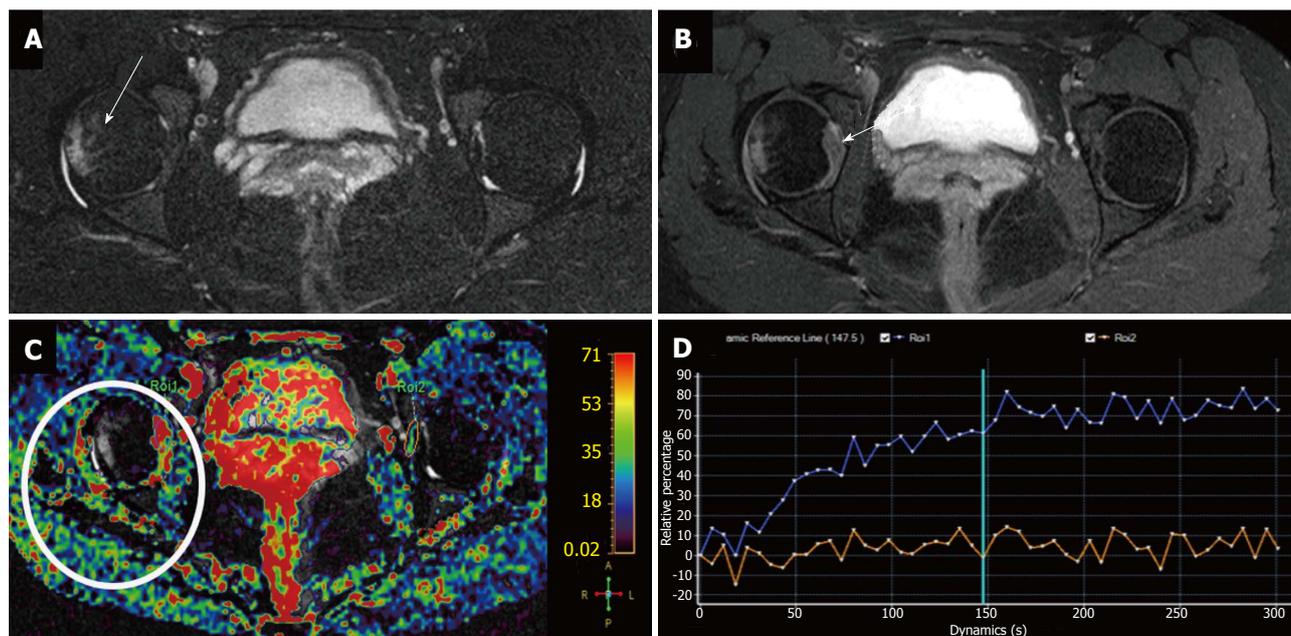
Evaluation of inflammatory arthritis with dynamic-contrast enhanced-magnetic resonance imaging in a 42-year-old woman with rheumatoid arthritis and right hip pain. A: Axial STIR shows mild articular effusion in the right hip with subtle signs of subchondral bone edema (arrow); B: Axial post-gadolinium SPIR GE T1-weighted image demonstrates moderate synovial thickening and enhancement especially at the medial articular surface (arrow); C: Relative enhancement map; D: Dynamic-contrast enhanced-magnetic resonance imaging demonstrate a type I TIC (blue curve) in the right hip, with progressive enhancement, compared to absence of significant enhancement in the contralateral hip (orange curve). This finding helps to confirm the inflammatory involvement of right hip. STIR: Short inversion time recovery.
